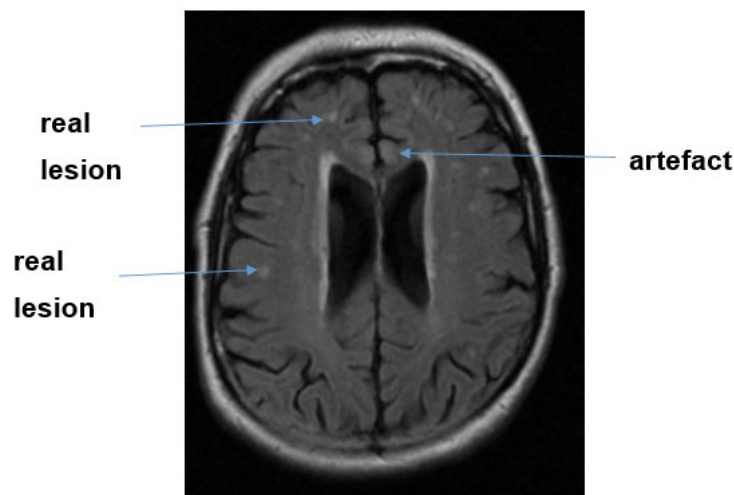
Axial FLAIR image showing real punctuate lesions in the deep white matter and artefacts in the CSF/tissue interface.
